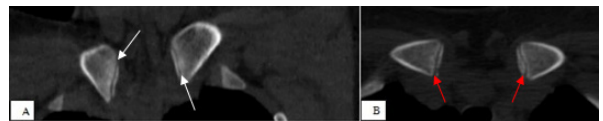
(A, B) CT image of medial clavicles in a 17 year old female shows stage 2c ossification of bilateral epiphyseal cartilage on the coronal image (A, white arrow) and on the axial image (B, red arrows)
